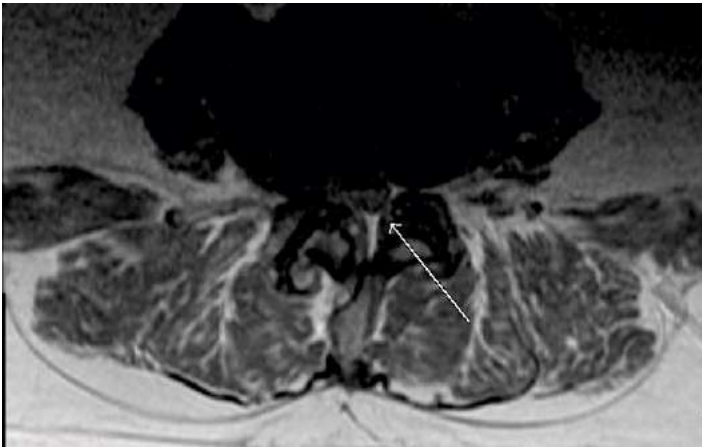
Axial post-contrast T1 MRI with lumbar nerve root enhancement at L4
